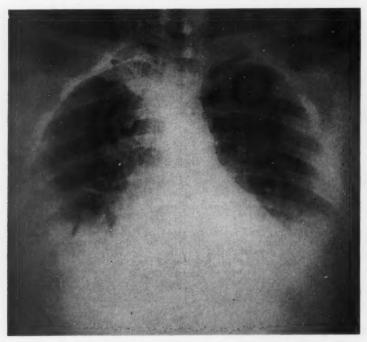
Case 1. Bedside chest x-ray, 4/21/55, one hour before bilateral thoracentesis yielded 350 ml. from the left hemithorax and 250 ml. from the right (total amounts obtainable). X-ray report: "Changes of pulmonary passive congestion . . . pleural fluid in the right and left hemithoraces, and in the horizontal fissure of the right lung."
